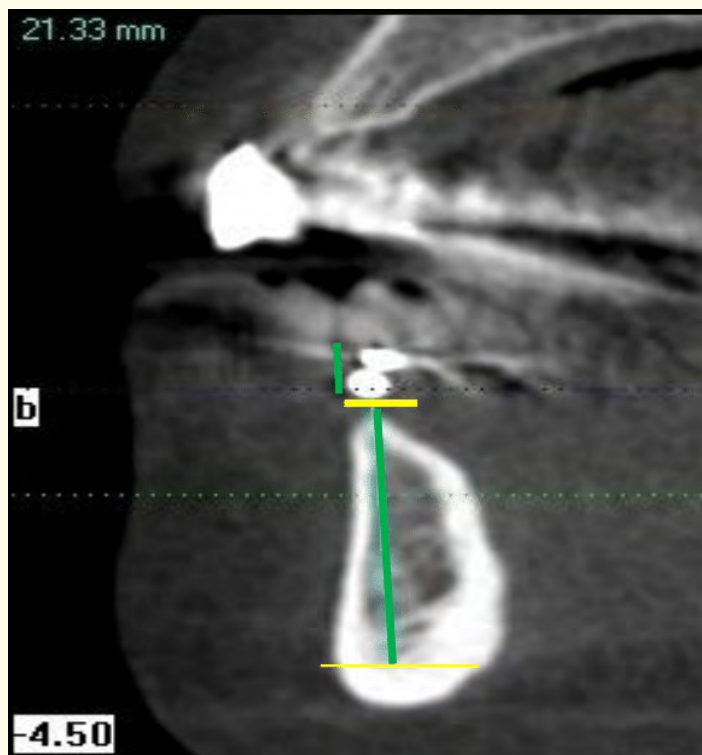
A cross-sectional CBCT image of one of the cases showing the performed measurement (green line) at the lower right second molar area from the mid-point of a tangent to the lower border of the marker (yellow thick line) to the mid-point of another tangent to the upper border of the mandibular cortex (yellow thin line) (M-IBM).
